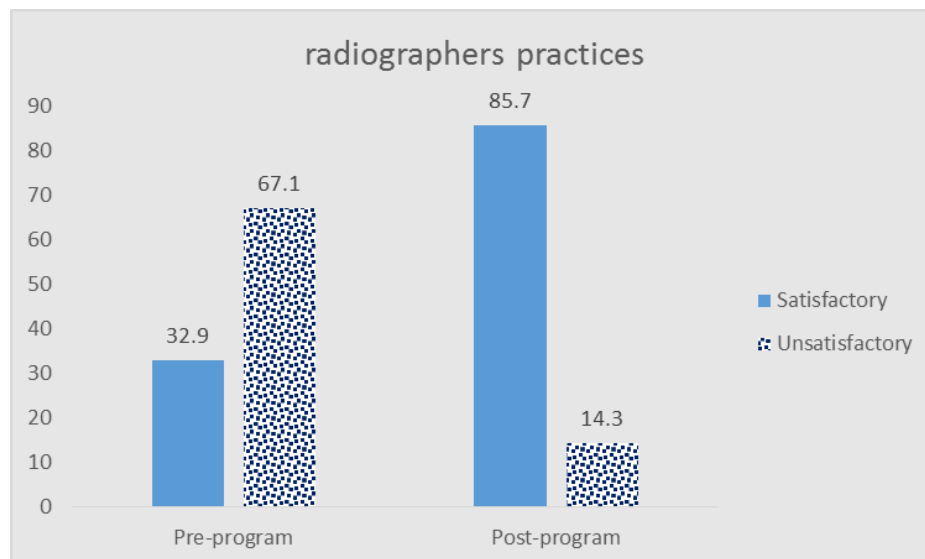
Distribution of studied radiographers regarding their total practices level pre and post program (n=70).
